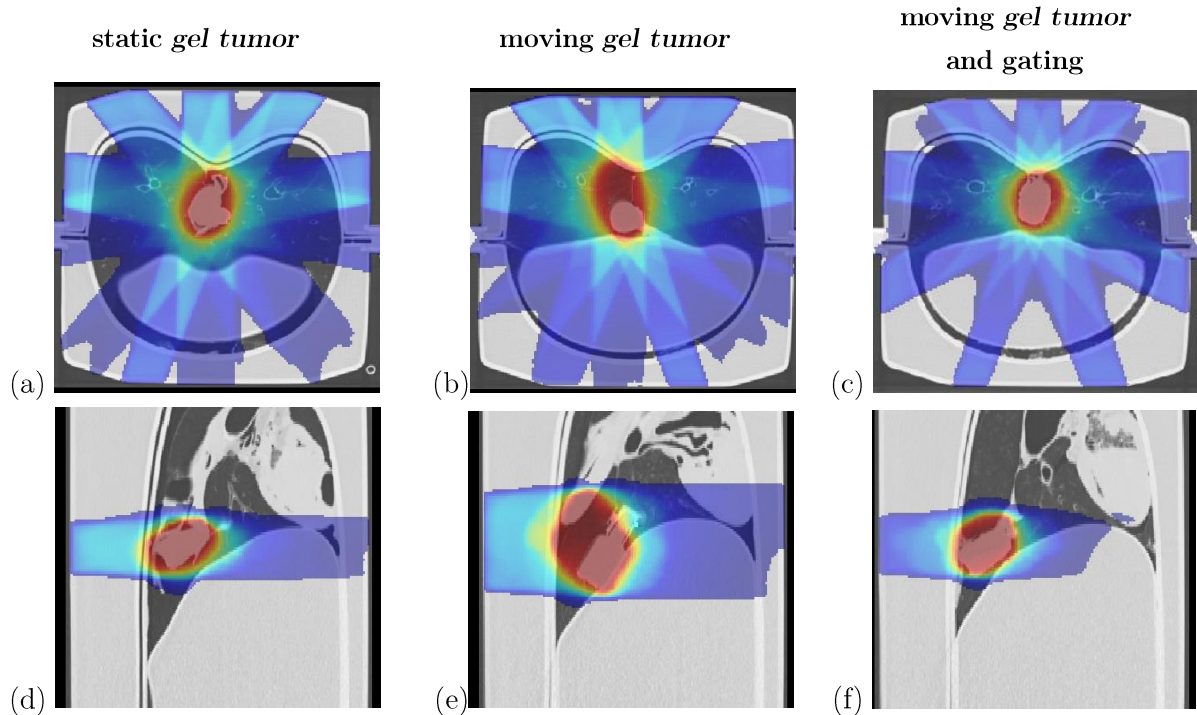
Planning CT (grey) and superimposed calculated dose distribution (colored) for a *gel tumor* irradiation in the (1) static ((a), (d)), (2) dynamic non-gated ((b), (e)) and (3) dynamic gated case ((c), (f)) for a representative transversal ((a), (b) and (c)) and sagittal ((d), (e) and (f)) slice. Nine intersecting beams (blue) are optimized to ensure a uniform PTV coverage (red area). As the *gel tumor* position could not exactly be reproduced, corresponding PTVs differ in shape and location. The beam width significantly varies for individual experiments and is largest for (2) followed by (3) and smallest for the static case (1).
